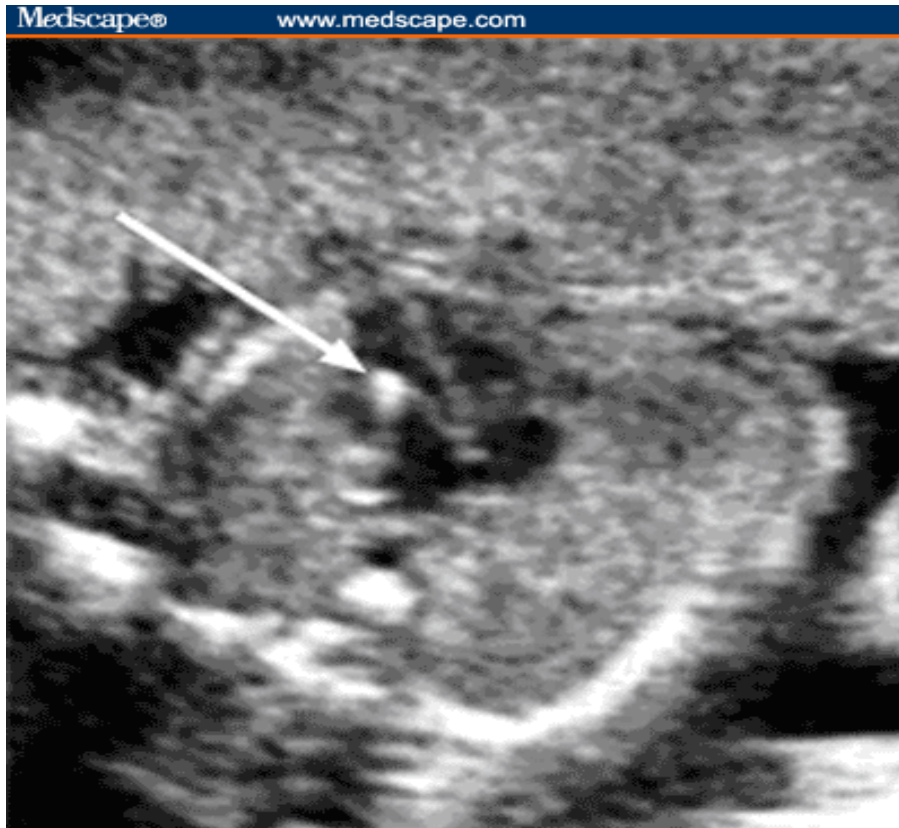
Echogenic intra-cardiac focus (EICF). This ultrasound image shows the fetal heart with a bright spot (arrow) in the left ventricle – the echogenic intra-cardiac focus.
